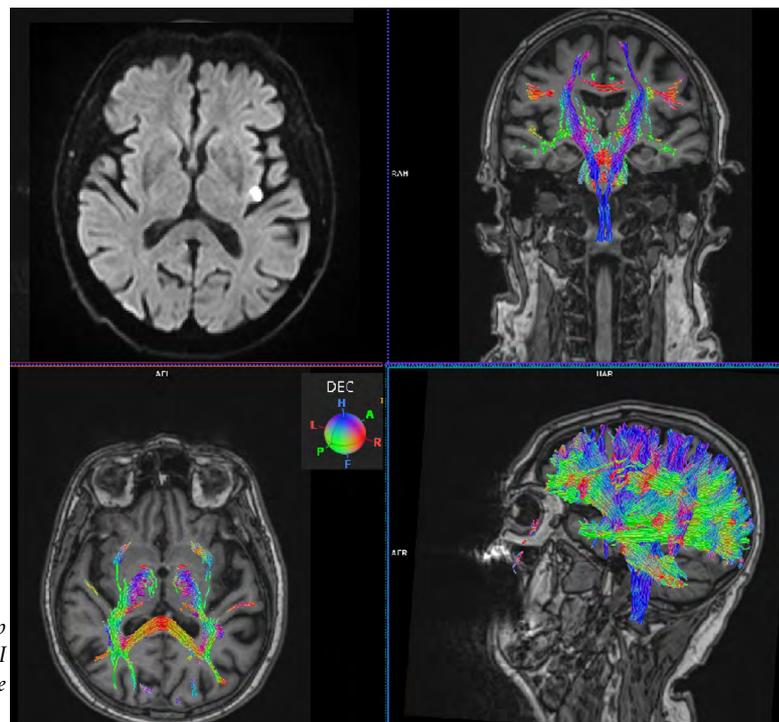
DWI b-1000 image in top left side. Fiber tractography from DTI acquisition on a 3D-T1 MRI sequence in top right and bottom side.
